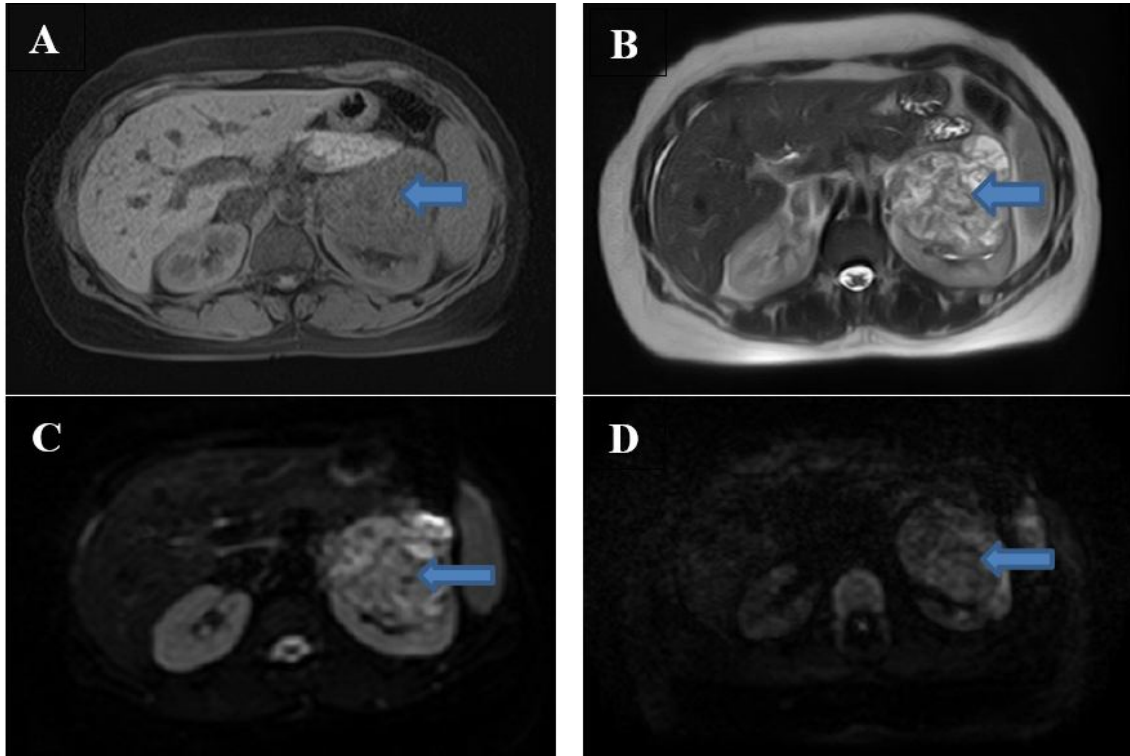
(A) Axial renal MRI (T1 sequence) shows left renal isointense mass, (B) Axial renal MRI (T2sequence) shows left renal heterogeneously intense mass, (C) Axial renal MRI (DWI sequence) shows facilitated diffusion, (D) Axial renal MRI (ADC) shows low signal. Patient underwent nephrectomy and pathology revealed diagnosis as left clear cell RCC
